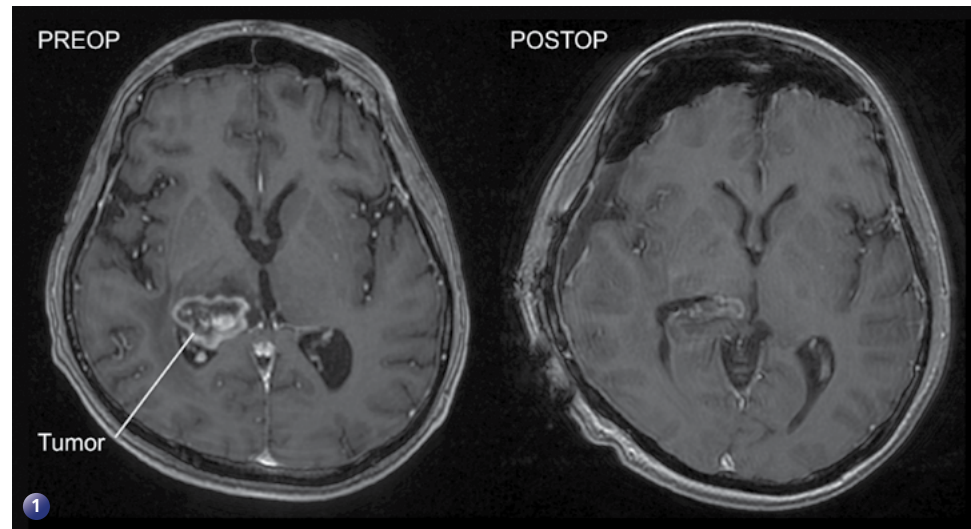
Preoperative and postoperative T1-weighted axial sections with contrast showing a subtotal resection of a right posterior thalamic tumor.
